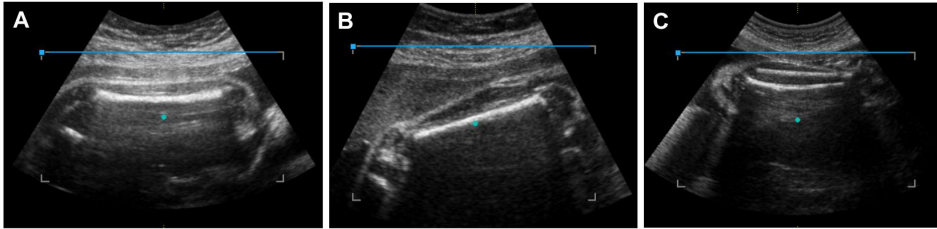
Three-dimensional ultrasound images showing the initial planes for three-dimensional volume acquisition of femur longitudinal-90(A), femur longitudinal-45 (B), and the tibia and fibula (C).
